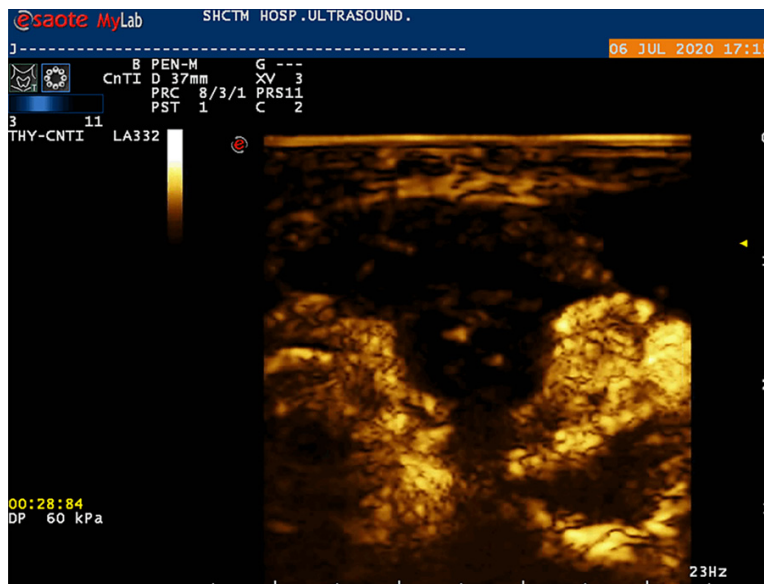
The solid components of the nodules showed the 'cavity sign' with no enhancement after contrast-enhanced ultrasonography.
